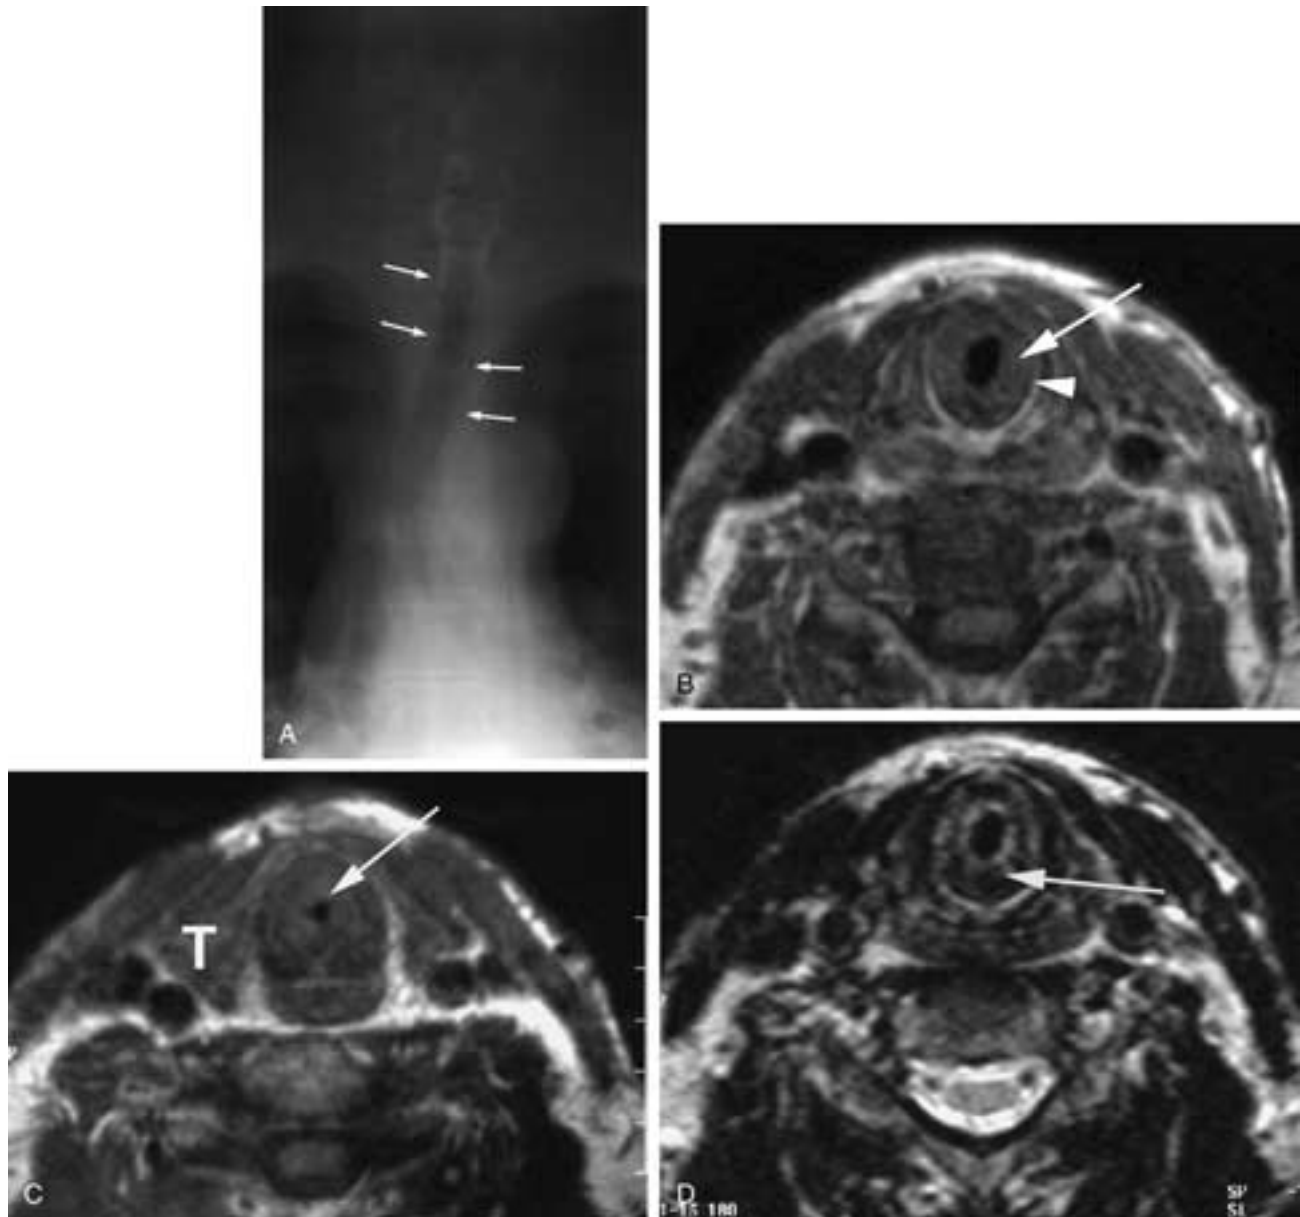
Amyloid. A, Chest radiograph of a 65-year-old man demonstrates a diffusely thickened tracheal wall on the posteroanterior view (arrows). B, T1-weighted MR image through the lower cricoid shows diffuse concentric soft tissue (arrow) narrowing the subglottic airway. The arrowhead indicates the position of the inner cortex of the cricoid cartilage. C, Axial T1-weighted image through the upper trachea shows the narrowing leaving a very narrowed airway (arrow). T, thyroid gland. D, T2-weighted axial image at the level of the lower cricoid shows that the abnormality has very low signal (arrow).
